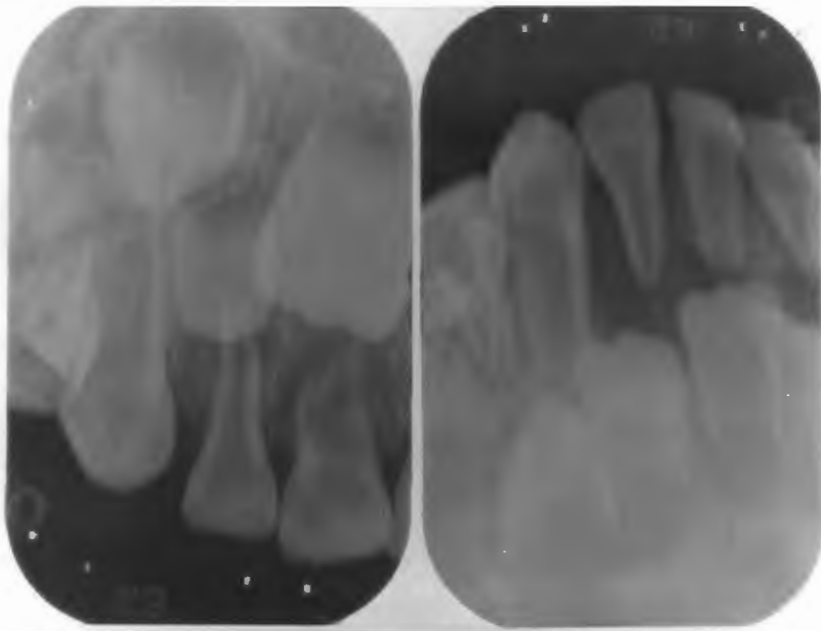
Periapical radiographs of the maxillary and mandibular anterior teeth of a male (Case 1) taken at initial examination. Note enlarged pulp chambers and periapical radiolucencies associated with the incisor teeth.
